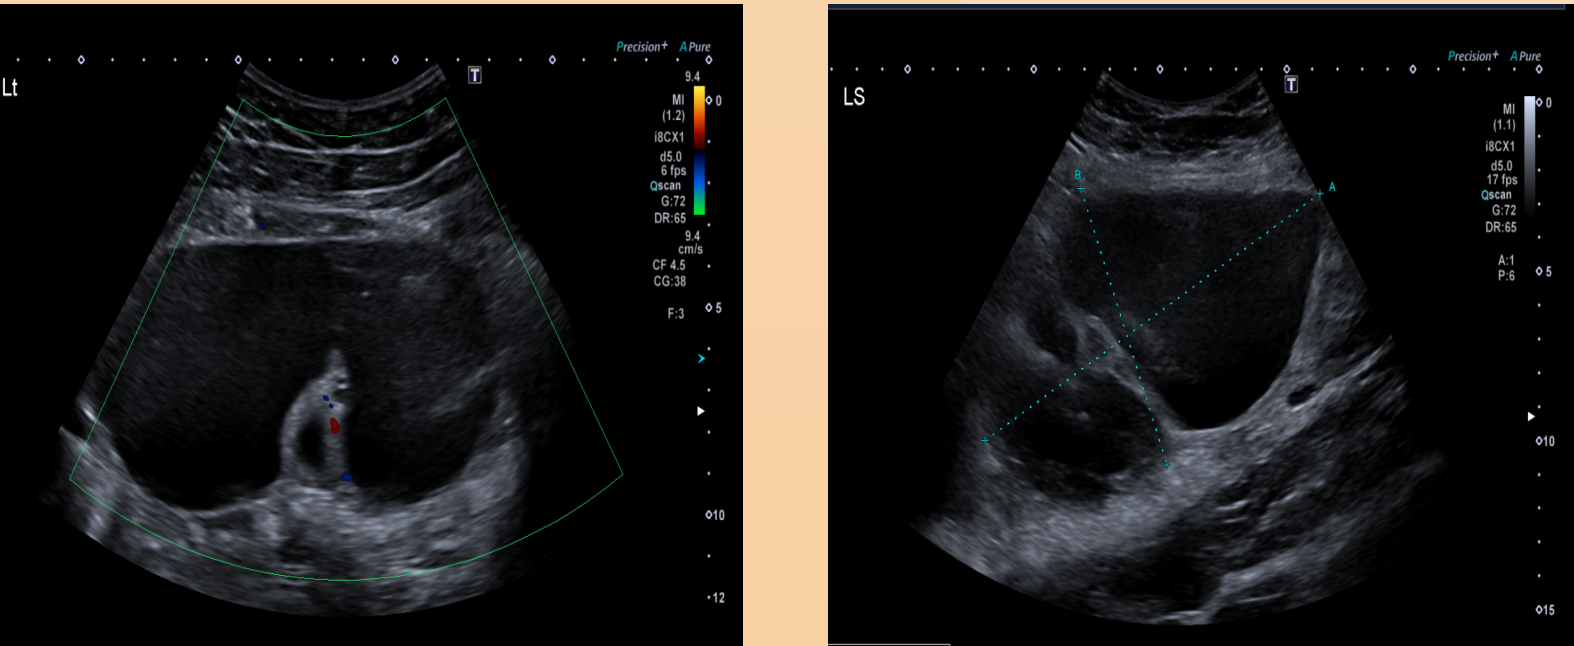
Ultrasound at 11 weeks gestation showing a large left adnexal complex mass.
